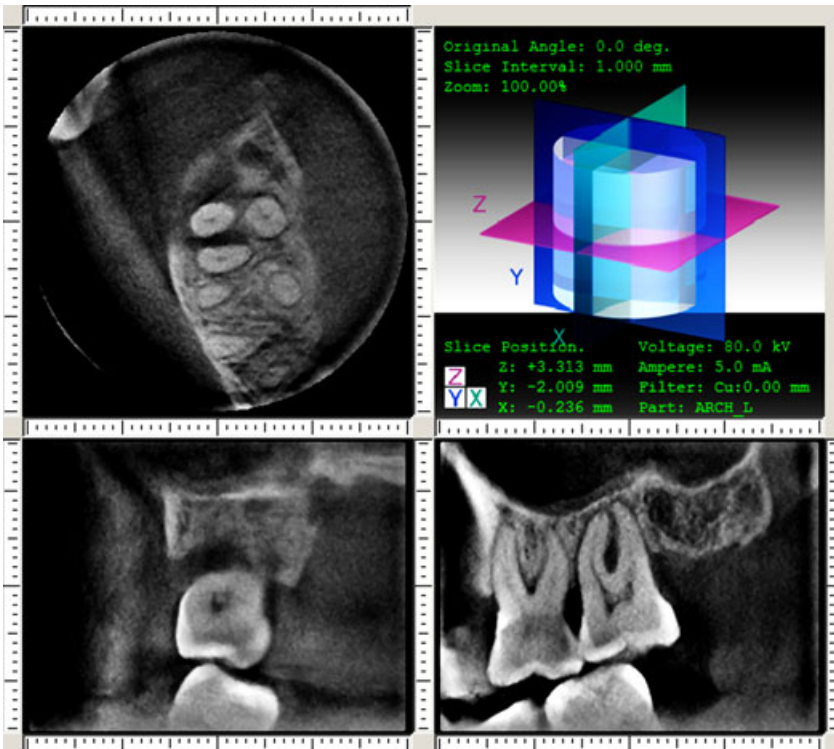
CBCT with horizontal, sagittal and transverse sections of the first and the second left maxillary molars (subject No. 5).
